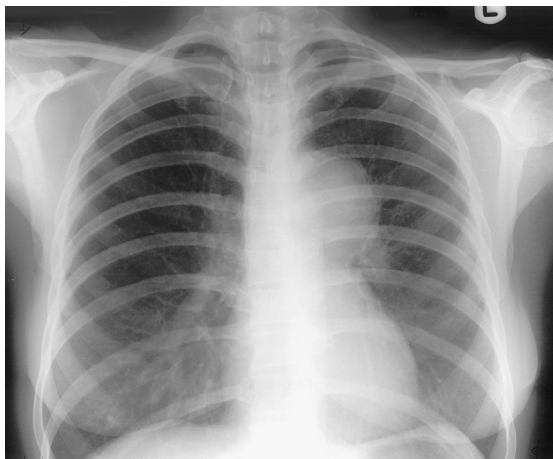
Chest radiograph showing primary bronchial carcinoma behind left hilum.
